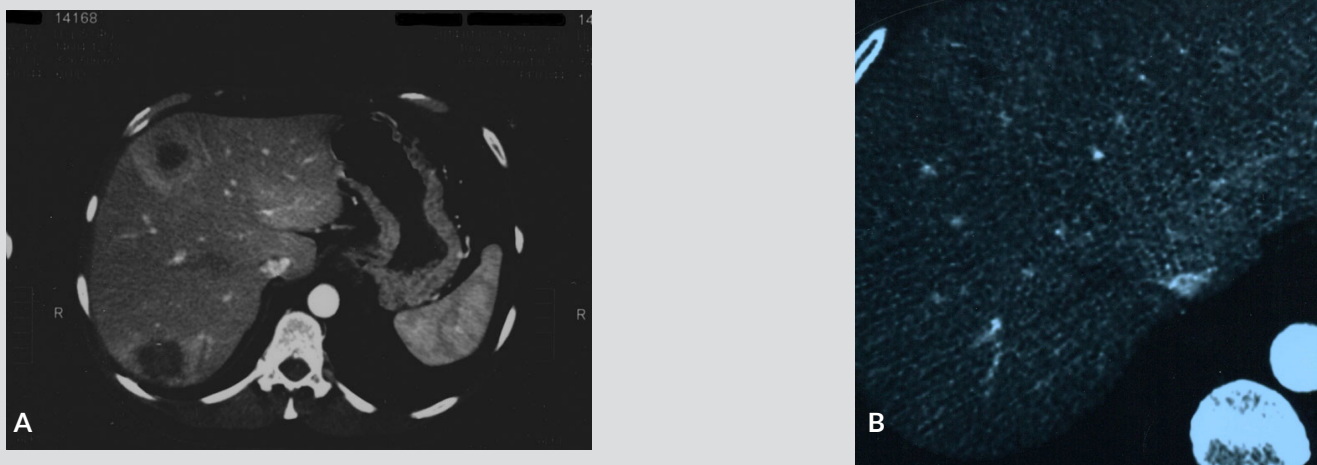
Abdominal Computed Tomography. A: Before treatment, the scan shows three hypodense lesions in liver segments VIII, IV and VII, with a slightly hyperdense peripheral halo during the arterial phase of examination. B: after treatment, the lesions have no contrast enhancement and are smaller in size.
